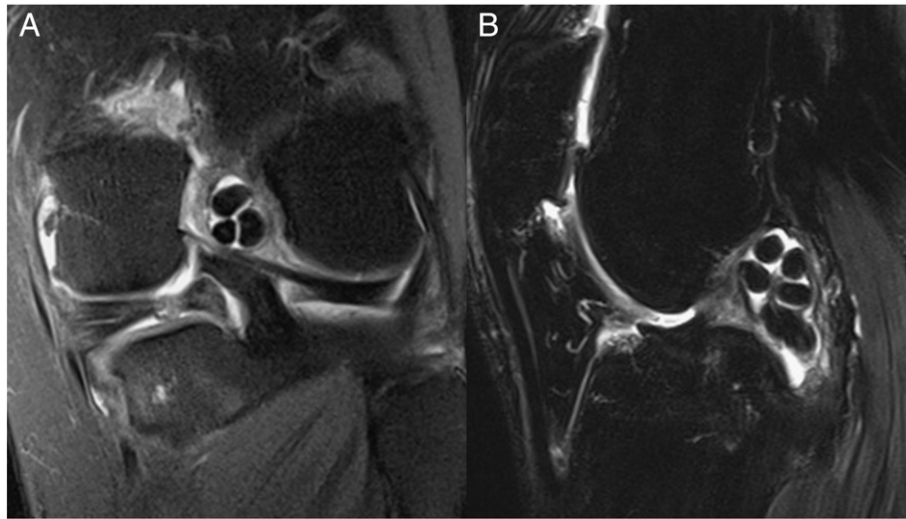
Magnetic resonance imaging. T2 coronal (A) and sagittal (B) views. Note the multiple loose bodies and increased signal intensity in the synovium.
